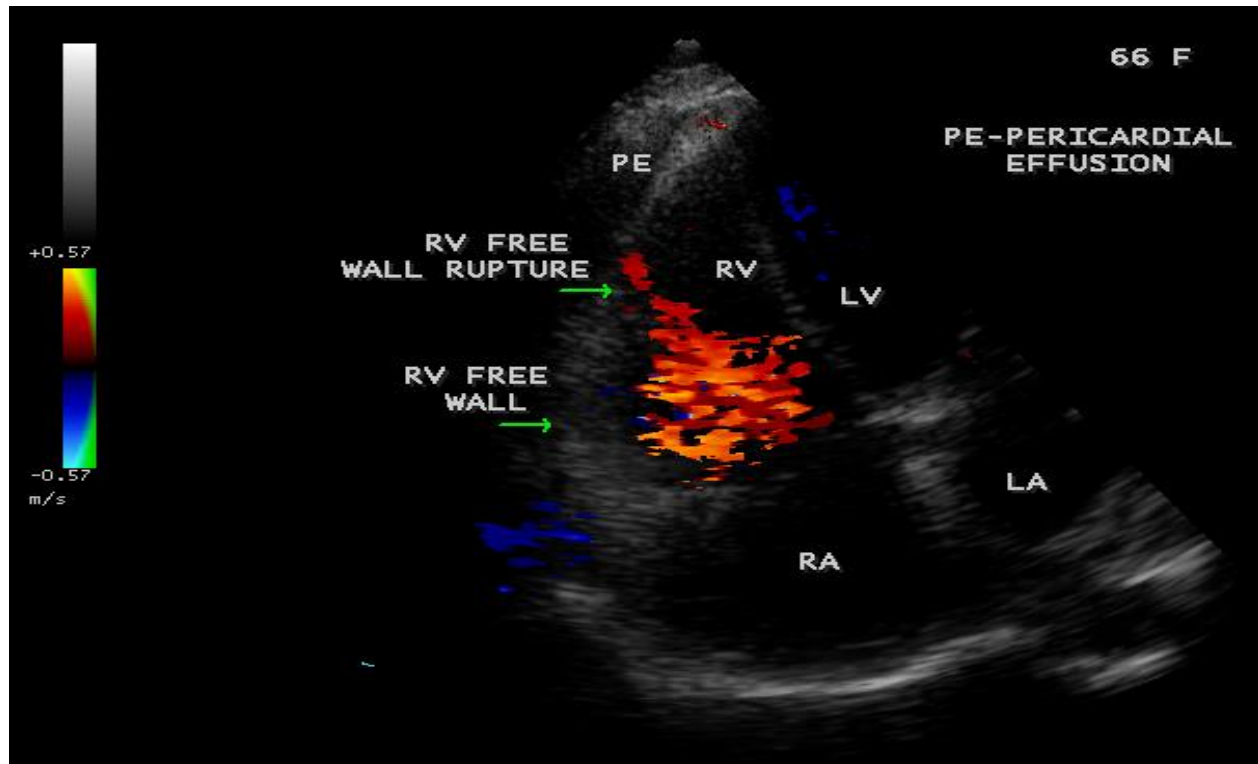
Color Doppler imaging showing the RV free wall rupture with a shunt into RV cavity in a 66-year old female with acute inferior wall infarction.
